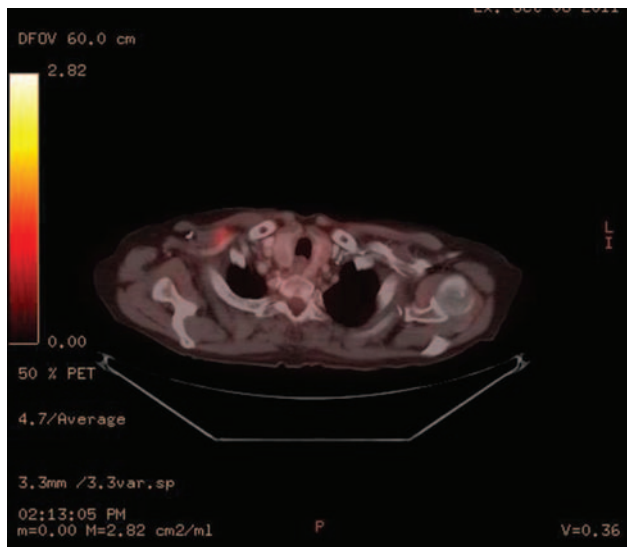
PET-CT scan with the enhancing right subpectoral lymph node.
